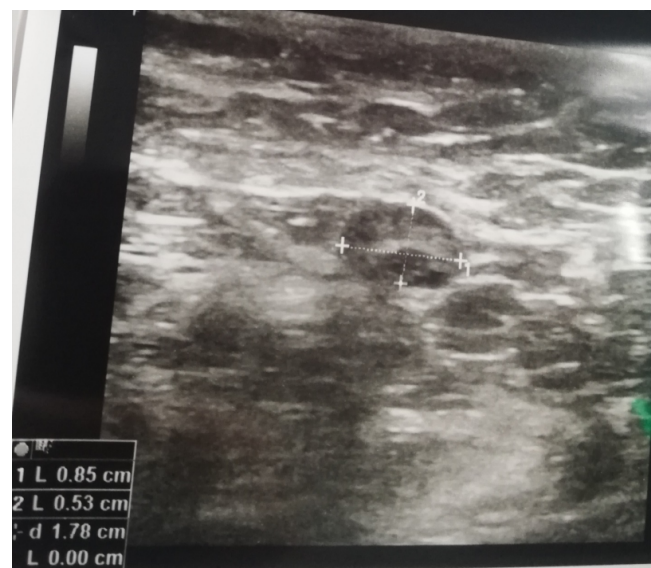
Sonographic image of 29 years old Miss Zunaira showing lymph nodes in axilla measuring 8.5\*5.3mm in the left breast.
